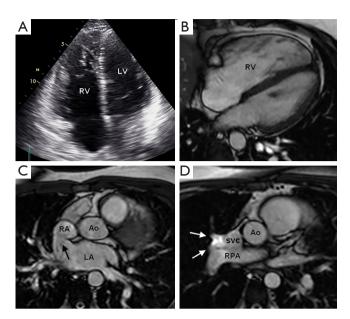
(A) 4-chamber apical TTE image showing a dilated hypertrabeculated and volume loaded right ventricle; (B) 4-chamber SSFP MRI image confirming right ventricular enlargement and flattening of the interventricular septum in keeping with volume loading; (C) Axial SSFP MRI image through the superior aspect of the interatrial septum showing the sinus venosus ASD (arrow); (D) Axial SSFP MRI image slightly cranial to (C) showing anomalous venous return of the right superior pulmonary vein into the distal SVC (arrows). RV, right ventricle; LV, left ventricle; Ao, aorta; LA, left atrium; RA, right atrium; RPA, right pulmonary artery; TTE, transthoracic echocardiogram; SSFP, steady state free precession; SVC, superior vena cava; ASD, atrial septal defect.
